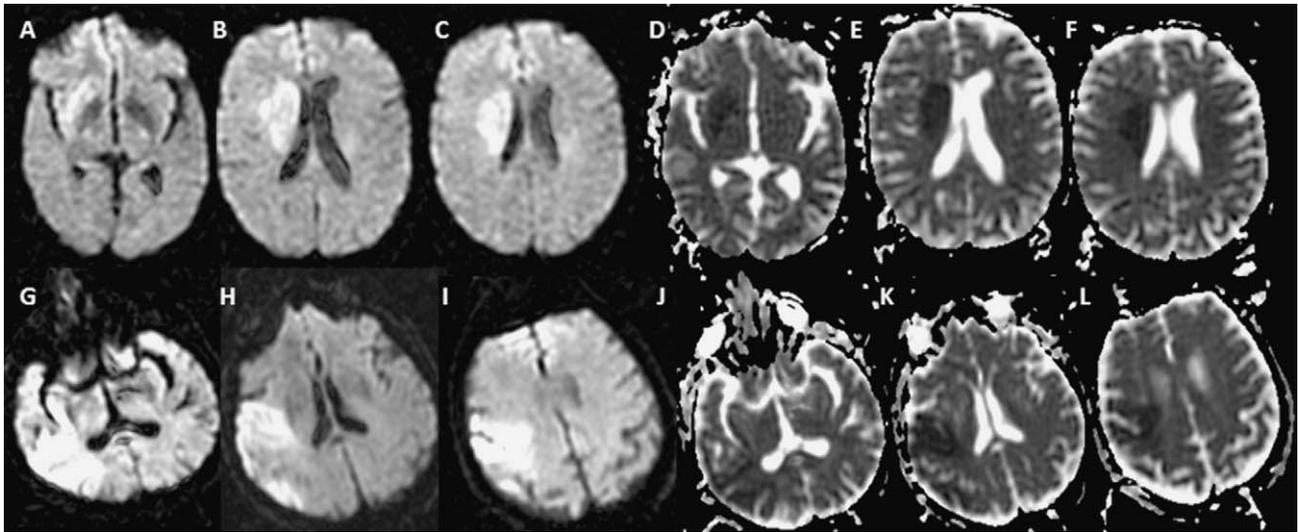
Two patients well predicted by ADC values in the ipsilesional putamen at H2, and not by DWI lesion volume. The first row concerns a 74-year-old woman with a right deep MCA territory stroke. DWI (A, B, C) lesion volume at H2 was 28.5 cm^3 , and predicted a good outcome. Indeed, ADC values (D, E, F) in the putamen and the CST were low (572 and $677 \times 10^{-6}\text{ mm}^2/\text{s}$). This patient had a 3-month mRS of 5. The second row concerns a 67-years old patient with a right MCA superficial territory stroke involving M1. DWI (G, H, I) lesion volume was 86.4 cm^3 and predicted a poor outcome. Nevertheless, ADC values (J, K, L) in the putamen and the CST were normal (889 and $793 \times 10^{-6}\text{ mm}^2/\text{s}$). This patient had a 3-month mRS of 2.
